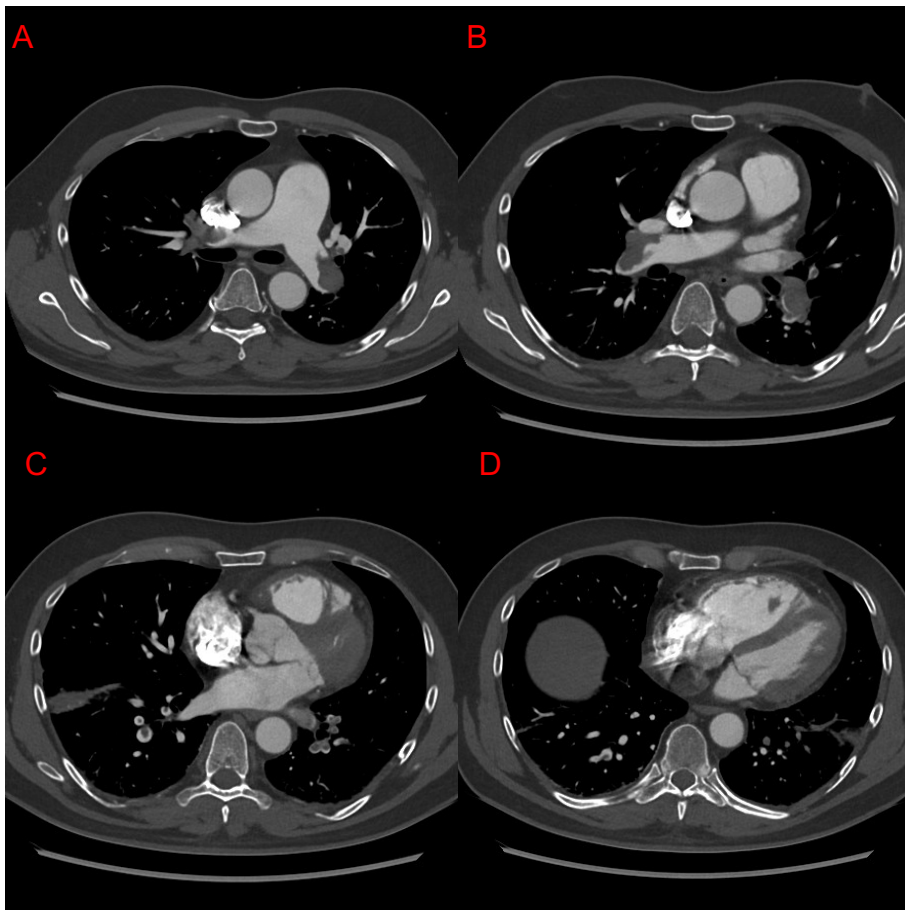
CASE 2: AXIAL CT WITH SEPTAL BOWING, ENLARGED TRUNCUS PULMONALIS, AND PE
